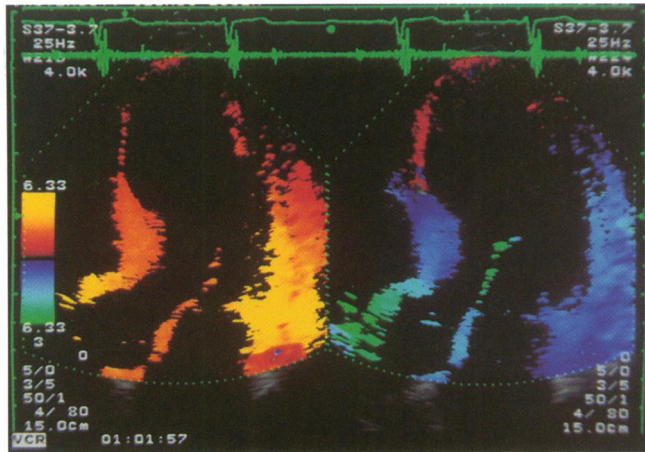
Apical four-chamber tissue Doppler echocardiogram, showing asynchrony of the left ventricle caused by coronary artery disease. During systole (left) the apex is colour coded red (outward motion) and during early diastole (right), the distal septum is colour coded red, indicating motion towards the transducer in a direction opposite to that of the lateral wall or proximal septum (colour coded blue).
